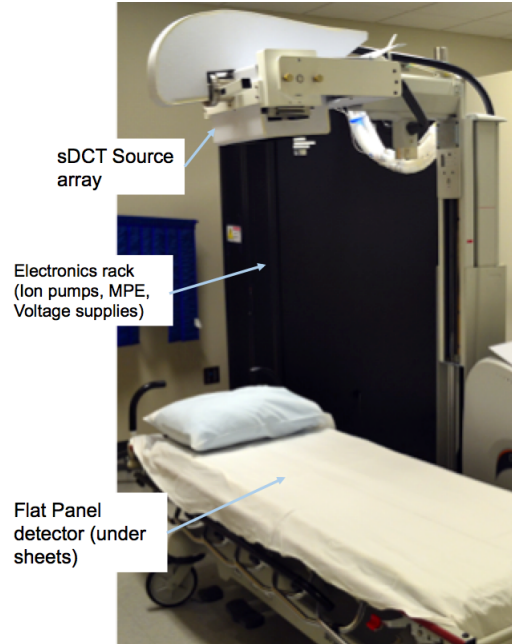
A photo of the clinical configuration of the s-DCT system. The CNT x-ray source array is covered and mounted above the bed. The electronics rack holds the equipment to monitor and drive the system. The flat panel detector is embedded in the patient bed mattress.
